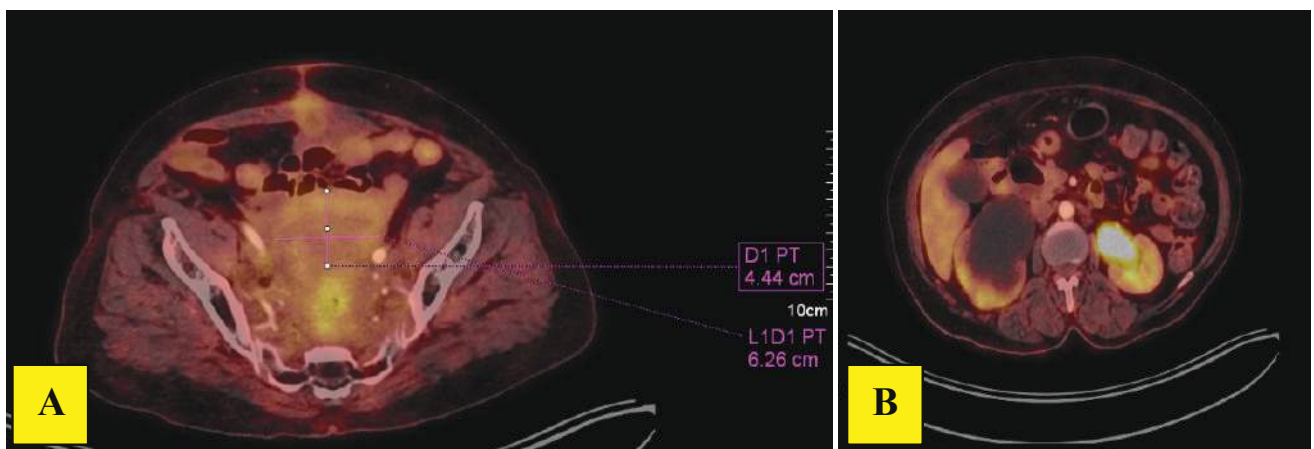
Axial fused PET/CT images showing a pelvic mass lesion measuring about 4.4 x 6.2 cm, with bilateral ureteral encasement & loss of posterior uterine fat plane (A), leading to bilateral hydronephrosis, more pronounced on the right side, with renal parenchymal thinning (B).
